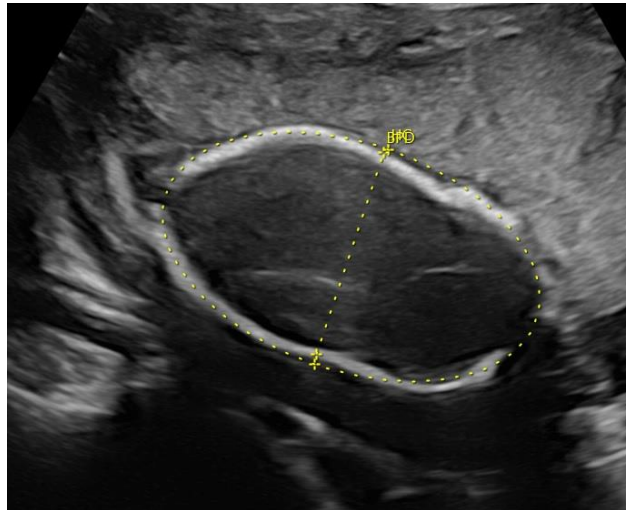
Skull Deformation in Fetal Demise. Ultrasound (Axial plane).
